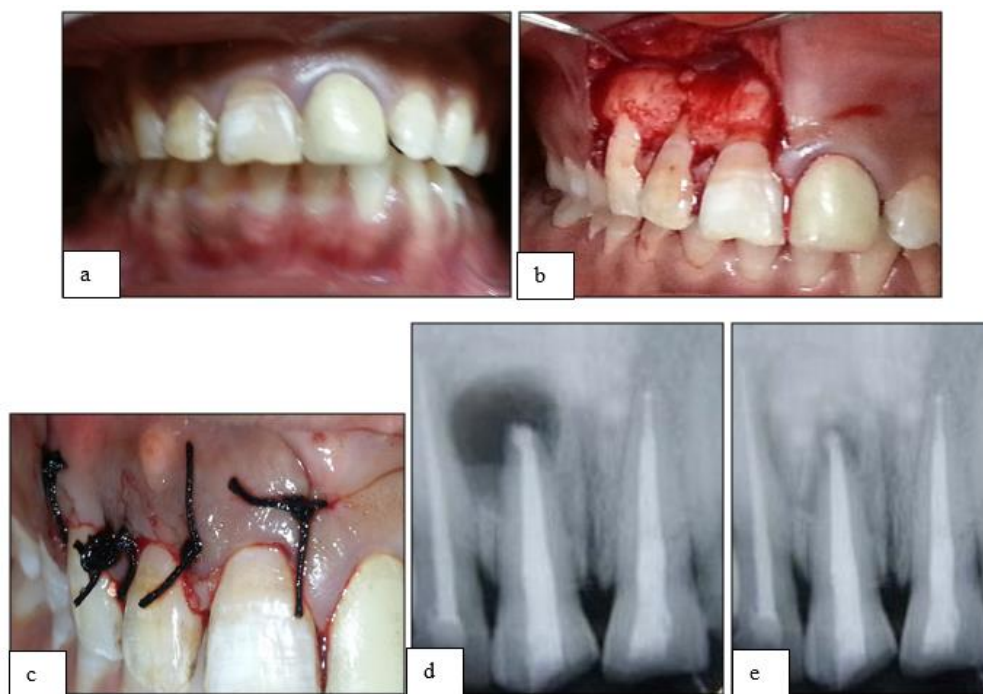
Preoperative #11; b: Flap raised and defect exposed; c: Suturing done; d: Immediate post-obturation radiograph; e: After 4 months
